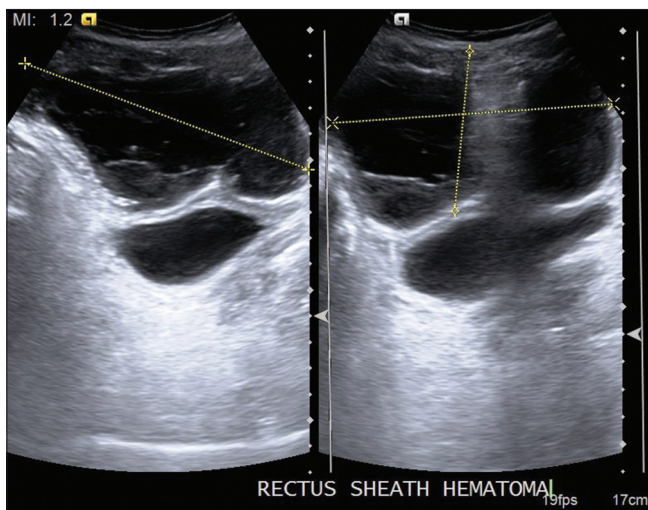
Ultrasound abdomen shows hematoma (10.7 cm × 5.9 cm) in the intra-muscular plane on the right lower abdomen
